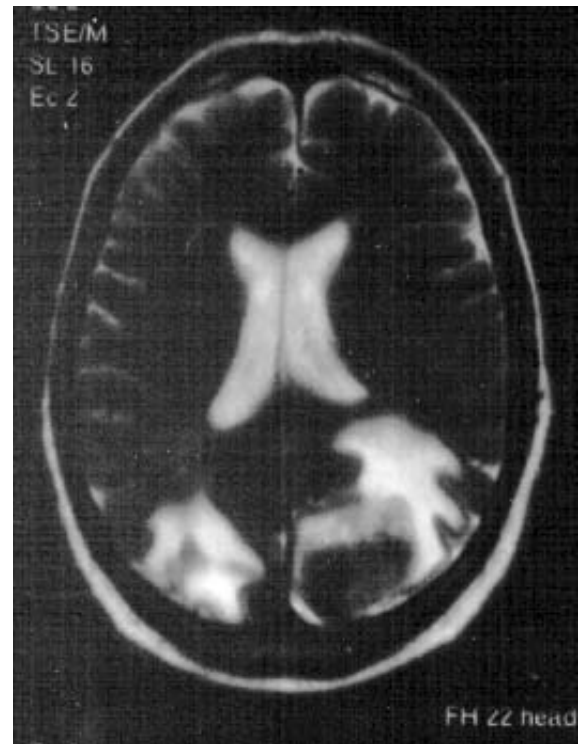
Patient 1: MRI scan taken 16 days after he developed symptoms of a stroke (courtesy of Dr Brunner, Kantonsspital Chur, Switzerland).
